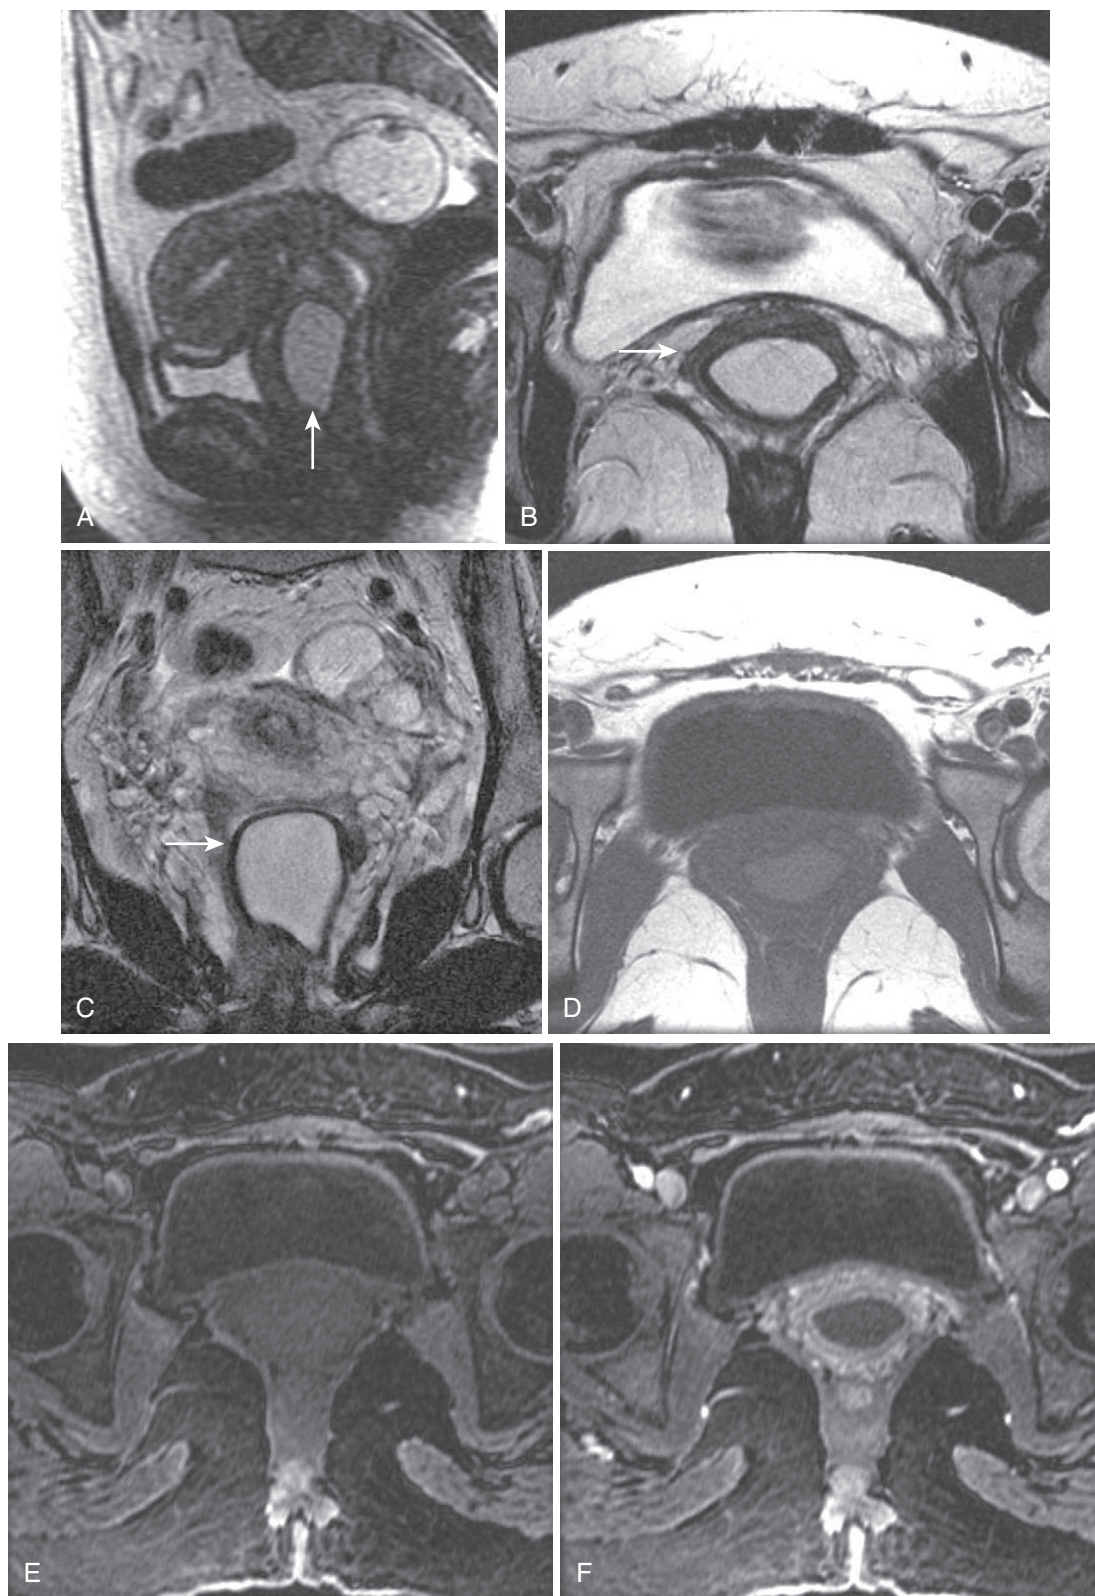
Gartner's duct cyst. Sagittal (A), axial (B), and coronal (C) T2-weighted images reveal a uniformly hyperintense lesion in the upper vagina seen to be anteriorly located on the sagittal image (*arrow*). Mild hyperintensity indicates proteinaceous content on the T1-weighted image (D), and lack of enhancement is reflected on the precontrast (E) and postcontrast (F) images.
